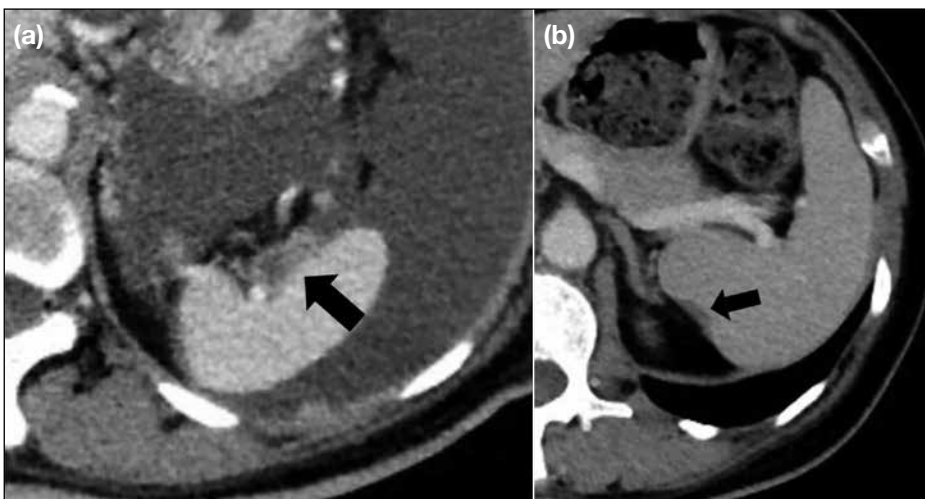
Contrast computed tomography images demonstrating deposit on the splenic surface, with (a) showing deposit at the splenic hilum (arrow) and (b) showing deposit at the posteromedial surface of the spleen (arrow). As these sites are difficult to assess on laparoscopy, pretreatment imaging is essential.
